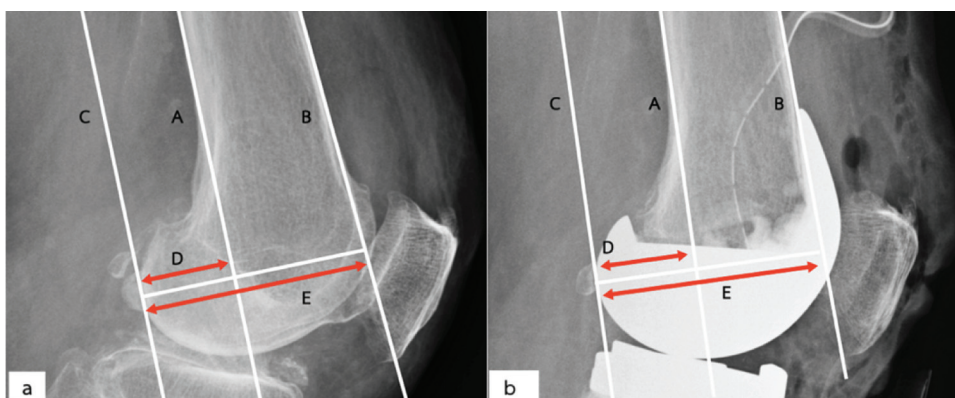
Preoperative (a) and postoperative (b) radiographs show PCO=distance of D and PCOR=ratio of D and E.
